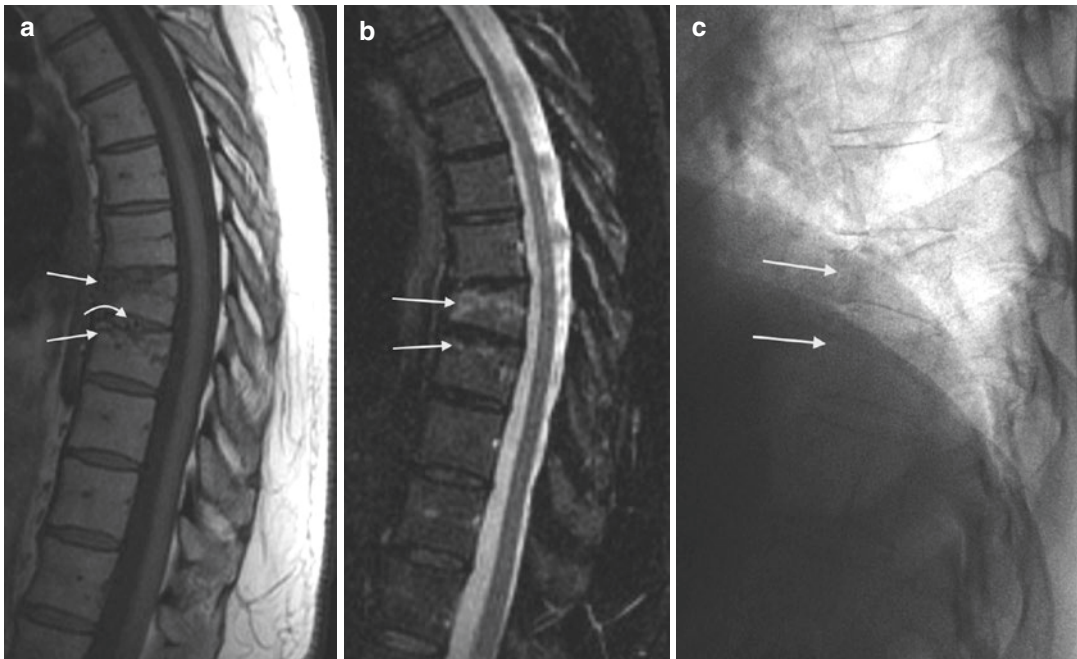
A 55-year-old female with 10/10 mid-back pain after a fall at work. T1-weighted sagittal image (a) shows two vertebral body compression fractures (arrows) with signal abnormality within the intervertebral disk
